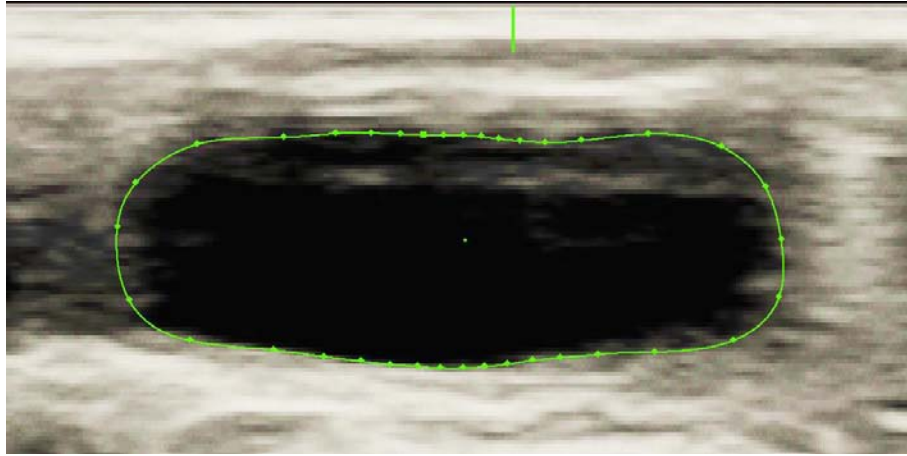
Example of an Ultrasound artefact causing a non-precise edge detection.
